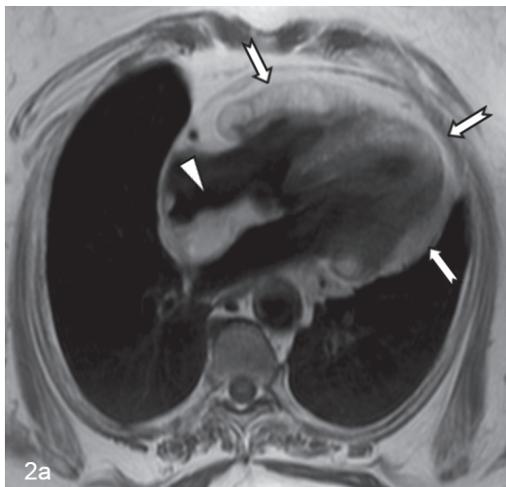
MRI four chambers view images a.T1W b.T2W TFE and c. STIR. The intramyocardial (⇔) and interatrial (▷) fat accumulation is depicted on T1W and T2 TFE images with identical signal intensity to that of the fat (high signal intensity) and typically with signal drop of on the corresponding STIR image (intramyocardial ⇔), interatrial (▷) confirming the presence of adipose tissue.
